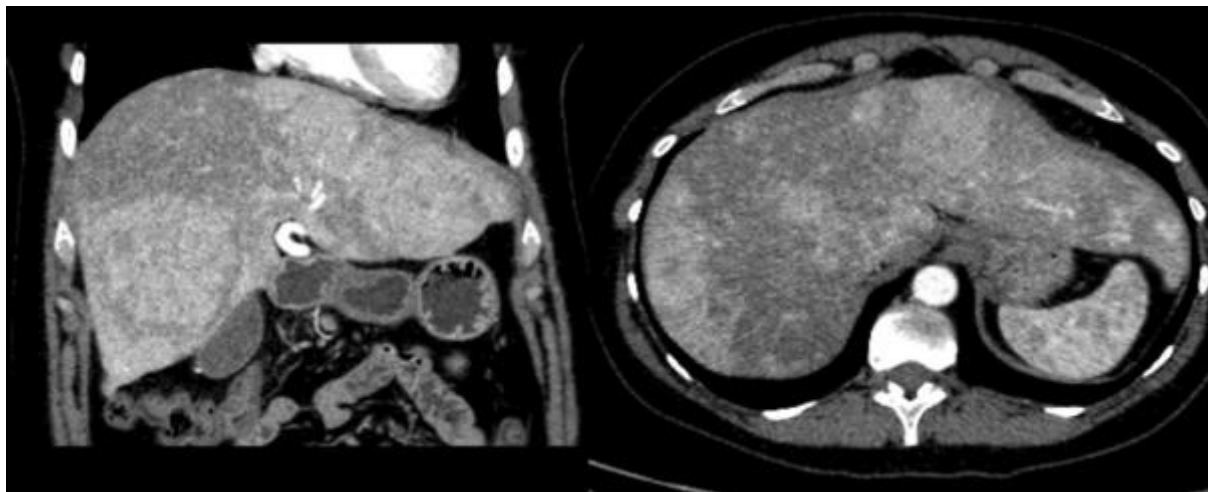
Coronal and Axial slices through CT scan imaging of a patient with HHT demonstrating the perfusional changes that can occur.
